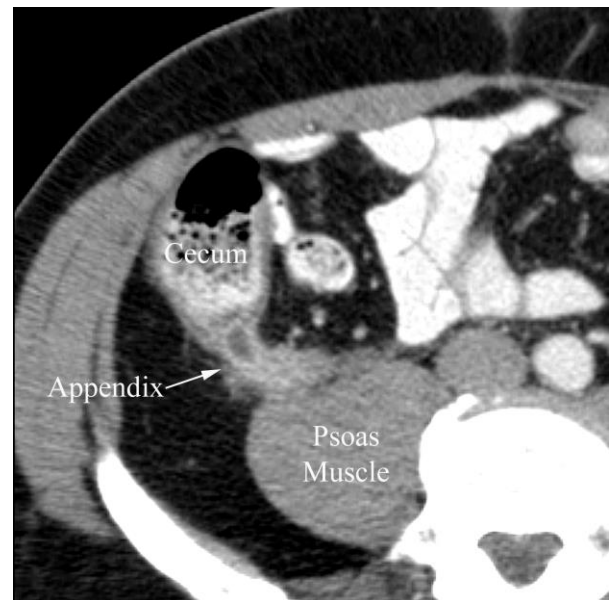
Appendicitis in a 52 year old man with right lower quadrant pain. CT study through the right lower quadrant performed with oral and IV contrast shows a swollen appendix with marked contrast-enhancement of the appendix wall along with periappendiceal fat stranding.
